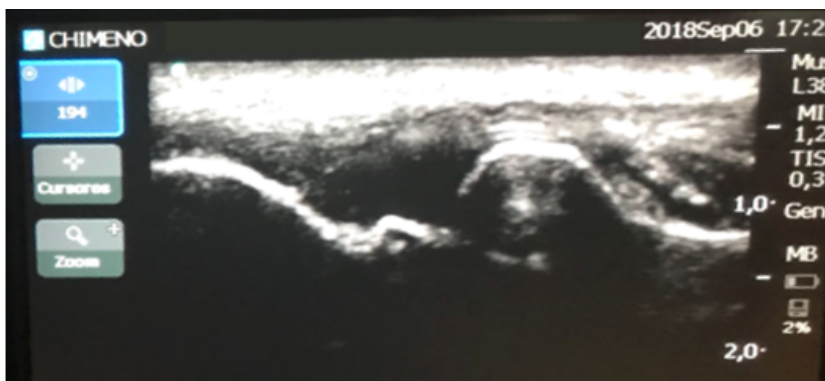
Ultrasound examination of the tendon of the lateral elbow. Own image.
